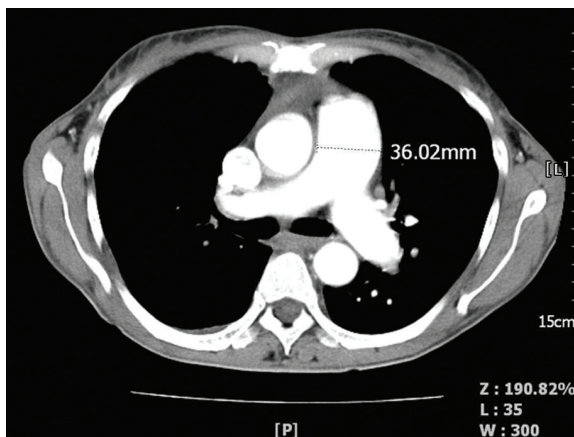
Size of main pulmonary artery is easily measured on CT scan. The size above 33.2 mm is highly suggestive of PH.
